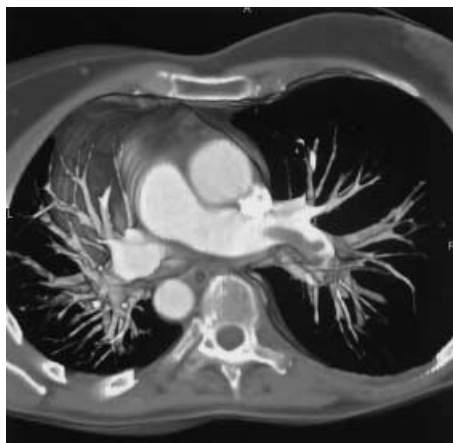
Acute pulmonary embolism (PE). A central embolus extends into the right main pulmonary artery. Multislice CT scan protocol: 2.5-mm collimation; pitch 6; total scan time 8 s. (Siemens, Forchheim, Germany) volume rendering seen from above
